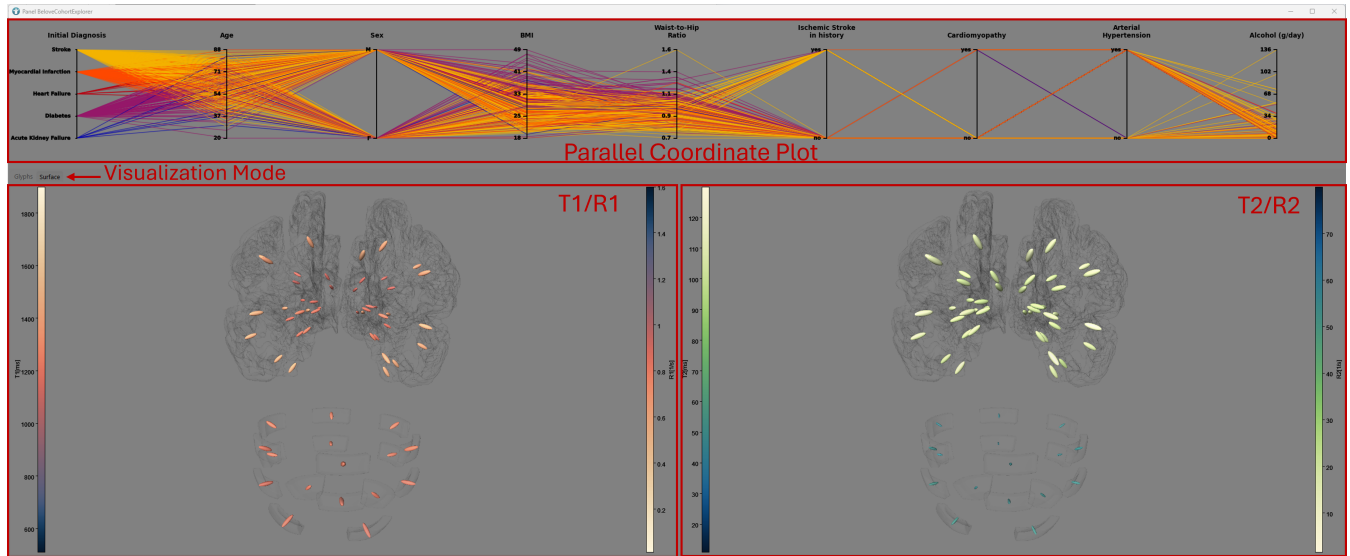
User interface for the cohort exploration. The upper part shows the interactive parallel coordinate plot with colors representing the patients' diagnoses for the BeLOVE study. The tabs enable the selection of the visualization mode. The selected 3D visualizations of the atlas-related analysis of the MRI relaxometry data is shown in the lower part of the user interface.
